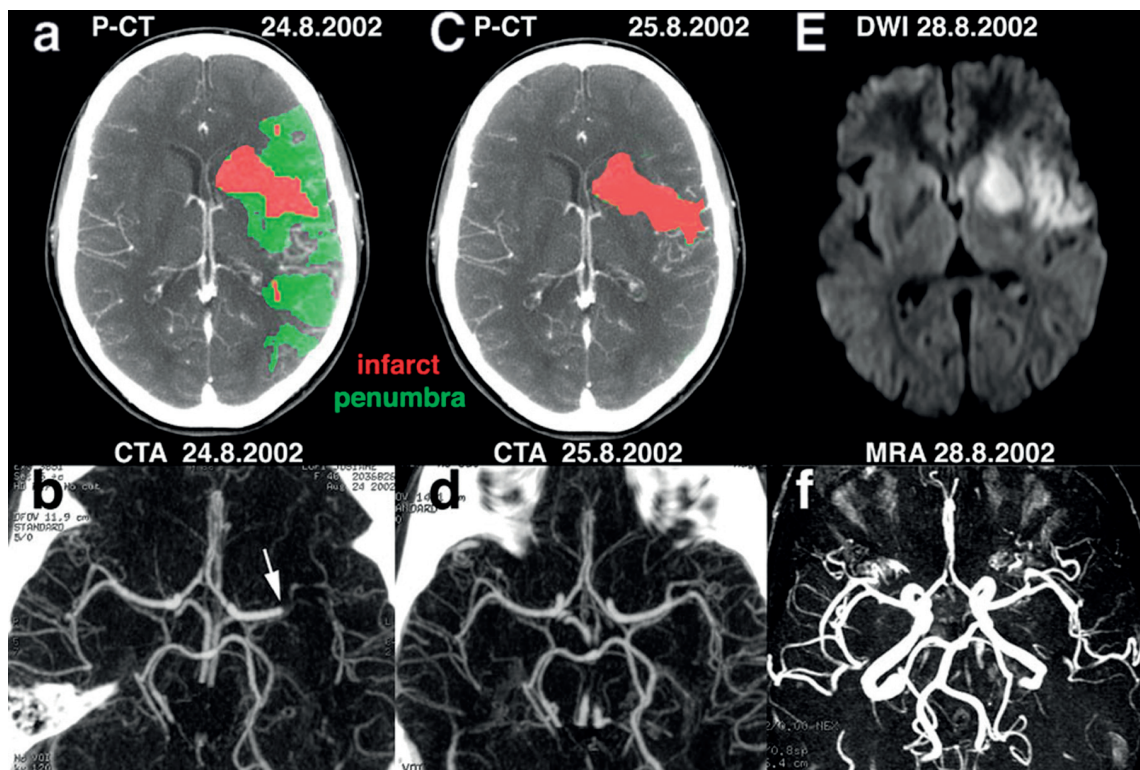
(A) Admission perfusion-CT demonstrates mixed infarct and penumbra in the left sylvian territory in a patient with a right hemisindrome, whereas (B) CT angiography (CTA) relates it to an occlusion at the left M1–M2 junction (*arrow*). The patient underwent intravenous thrombolysis and his clinical condition evolved favorably. Twenty-four hours after admission, (D) follow-up CTA features a recanalization of the left sylvian artery, later confirmed on the (F) MR-angiography (MRA). (C) Follow-up perfusion-CT shows an almost complete resolution of the penumbra, afforded by the early arterial recanalization. The final perfusion-CT infarct has progressed in only a very limited fashion when compared to the admission perfusion-CT infarct; its extent closely correlates with that of the abnormality on the (E) delayed DWI trace image.
